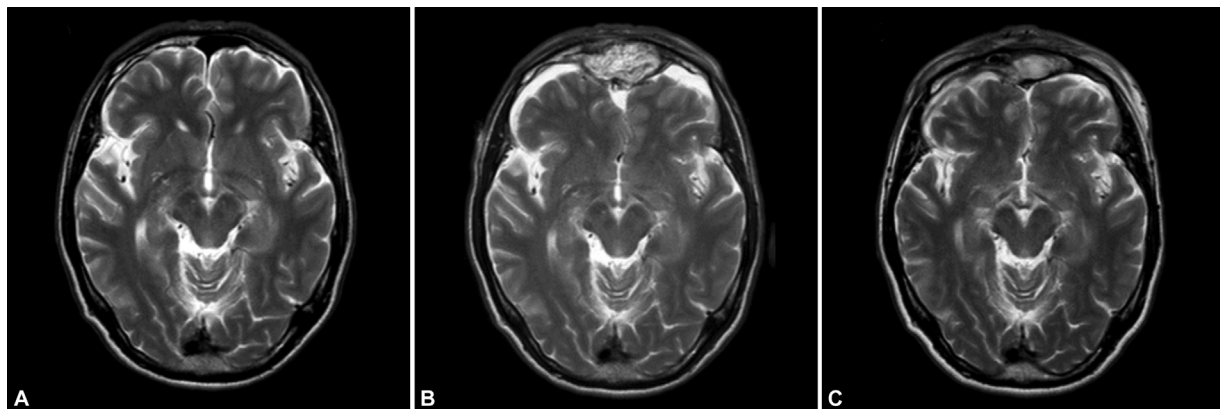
MRI findings in the patient with a postoperative subcutaneous abscess. (A) Preoperatively. (B) 1 week postoperatively. (C) 9 months postoperatively.
